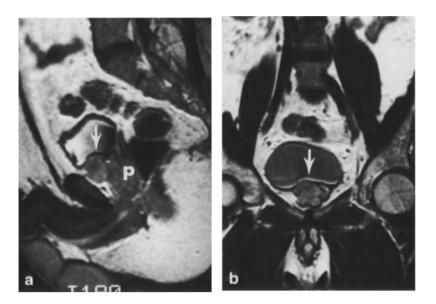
a,b. Pheochromocytoma (*arrow*) in the urinary bladder wall at the base, anterior to the prostate (*P*). a Sagittal and b coronal T1-weighted MRI. (Courtesy of Dr. I. YODER)
